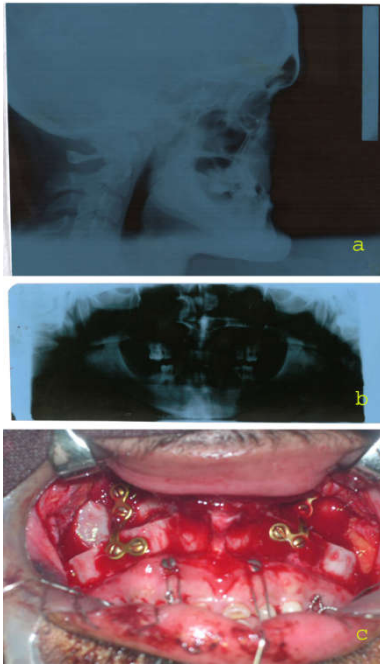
a) Preoperative Cephalogram b) OPG Radiograph and c) Stabilization of advanced maxilla using plates
